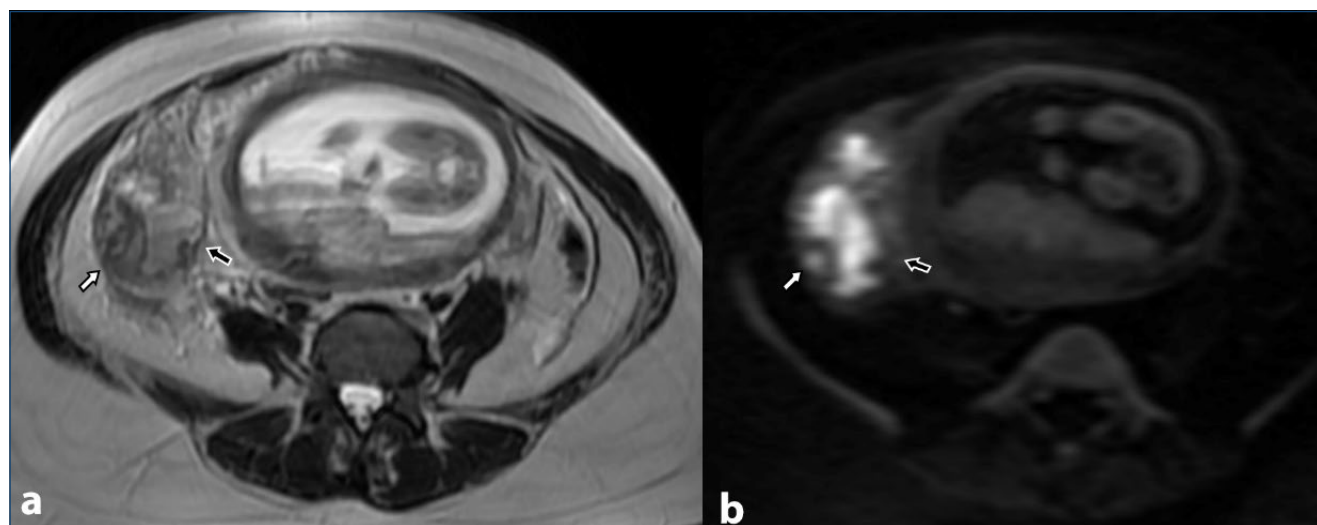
A 23-year-old pregnant patient in 21st week of gestation. Perforated appendicitis (white arrow) with free fluid, fat stranding, and abscess formation (black arrow) as shown on axial T2-weighted sequence (a) and on diffusion-weighted imaging (b).
